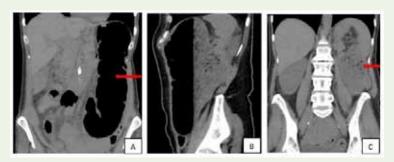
(A, B, C) Case 1: A 66-year-old male patient with a history of abdominal pain, nausea, vomiting, and suspected bowel obstruction; coronal non-contrast CT images demonstrate a typical Cecal volvulus with its apex in LUQ (arrow) dilated cecum, mesenteric oedema.
